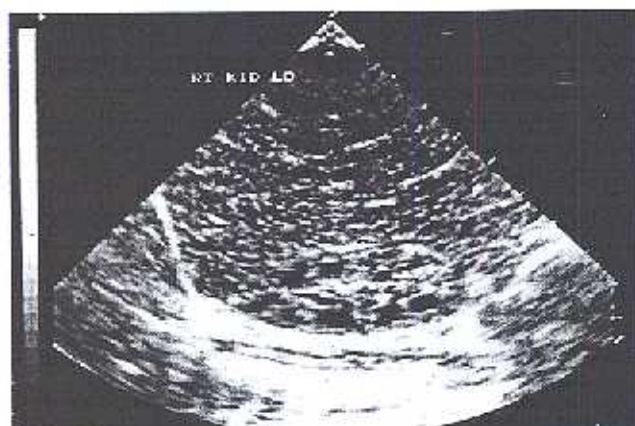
Longitudinal (LO) ultrasound of right kidney (RT KID) shows hyperechoic parenchyma with the exception of the renal pyramids
